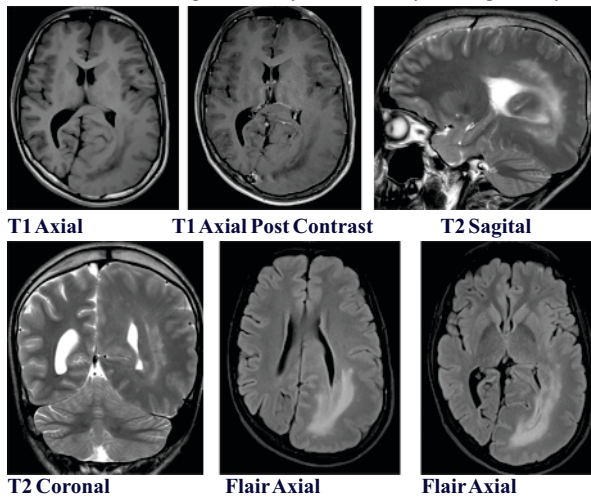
MRI Brain of 17 year old male patient with childhood seizure showing diffuse enlargement of left temporo-parieto-occipital lobe with sparing of ipsilateral frontal lobe and malformed posterior horn of left lateral ventricle with periventricular T2/FLAIR hyperintensity. Poor gray white matter differentiation, cortical thinning and focal cortical dysplasia in form of pachygyria and polymicrogyria involving mentioned left hemispherical lobe suggestive of posterior quadrantic dysplasia.
